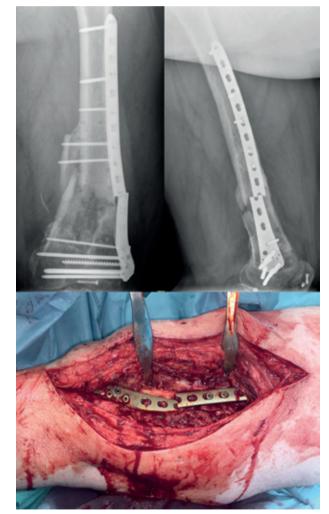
Induced membrane after cement removal and radiographs after RIMN and bone marrow and grafts positioning
